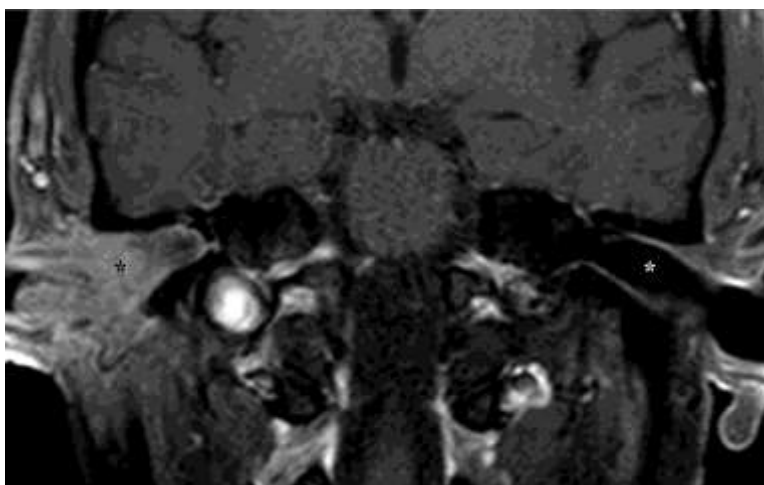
External ear cancer; coronal T1-weighted sequence with fat saturation acquired after i.v. administration of contrast medium. Contrast enhancing soft tissue mass (black asterisk) with undefined edges causing stenosis of right EAC and reaches the bony part of the EAC. Normal appearing contralateral EAC shows typical low signal due to its air content (white asterisk).
